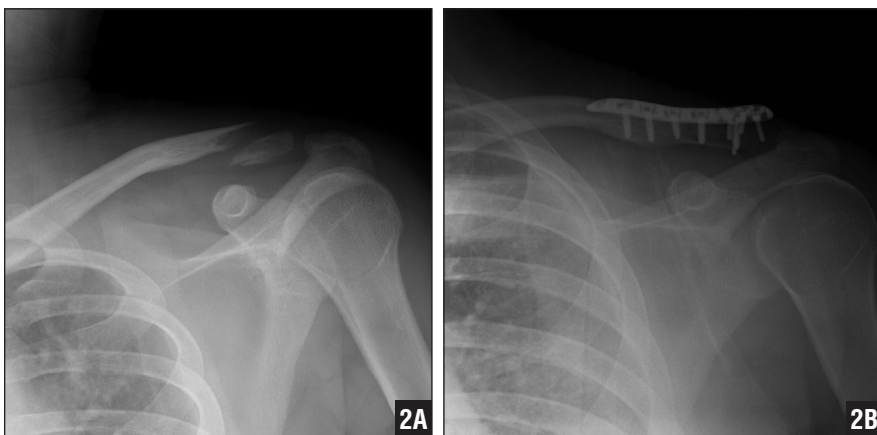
A 28-year-old man sustained a left distal clavicle fracture in a traffic accident. Preoperative anteroposterior radiograph showing a Neer type II fracture of the left distal clavicle (A). Immediate postoperative anteroposterior radiograph showing satisfactory reduction of the fracture (B).
